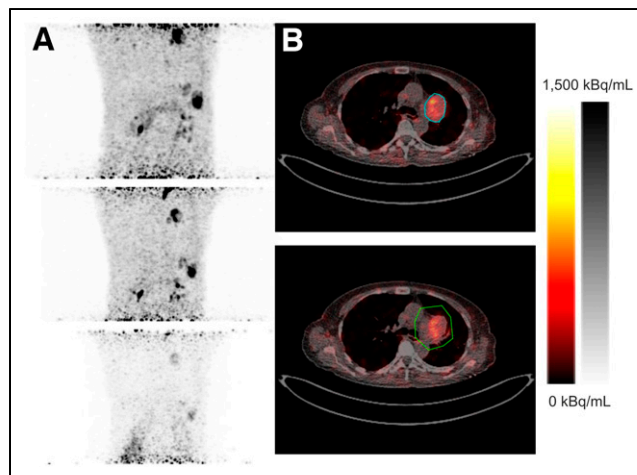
PET/CT imaging and lesion delineation for patient 1.  $^{90}\text{Y}$ -FAPI-46 PET MIP images (A) and axial PET/CT images (B) show contour-based VOI (blue) and oversized VOI (green). Only first 2 PET data points were considered for tumor absorbed dose estimation.
